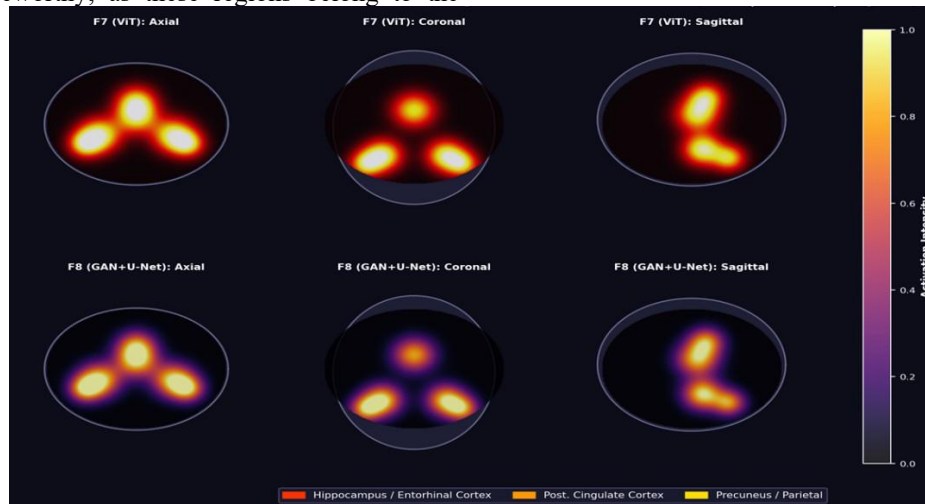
Gradient-weighted Class Activation Maps (Grad-CAM) overlaid on representative structural MRI brain volumes for model formulations F7 (Vision Transformer, top row) and F8 (GAN+U-Net, bottom row) across axial, coronal, and sagittal planes. Warm colours (red/orange/yellow) indicate regions of highest discriminative activation. Both models consistently highlight the bilateral hippocampus and entorhinal cortex (red), posterior cingulate cortex (orange), and precuneus/parietal regions (yellow), regions that are well-established neuroanatomical biomarkers of Alzheimer's disease pathology. F8 shows slightly stronger and more spatially focused activations than F7, consistent with its higher diagnostic accuracy.
